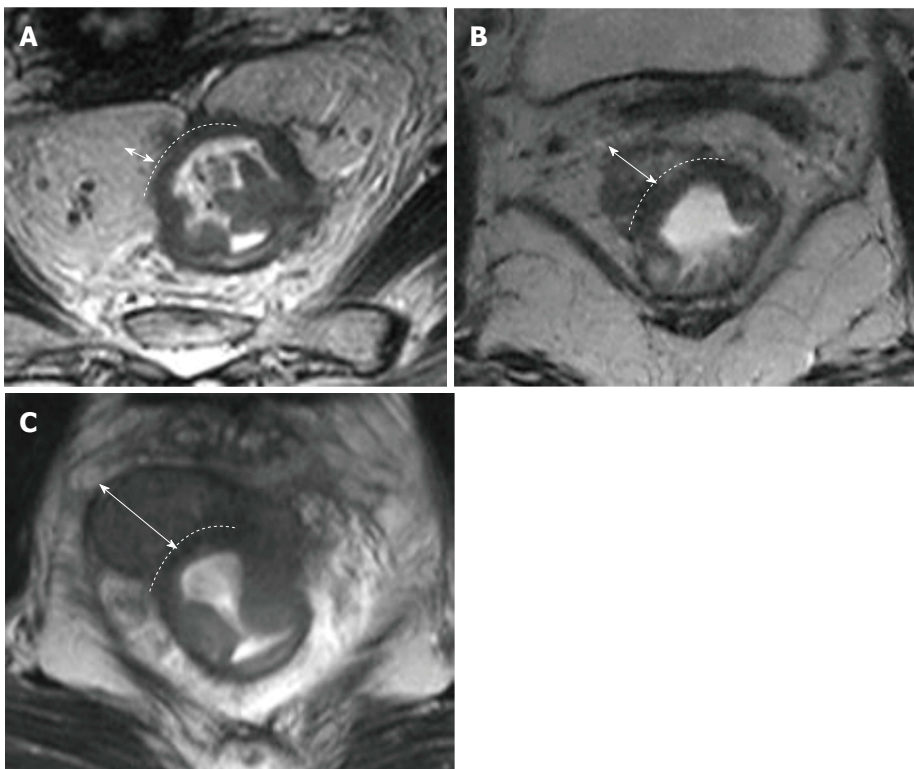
Stratification of T3 tumors on magnetic resonance imaging. T2-weighted axial magnetic resonance images in different patients with T3 rectal carcinoma showing extension of the tumor beyond the muscularis propria (double-headed arrows). The distance A: Less than 5 mm, T3a; B: 5-10 mm, T3b; and C: More than 10 mm, T3c.
